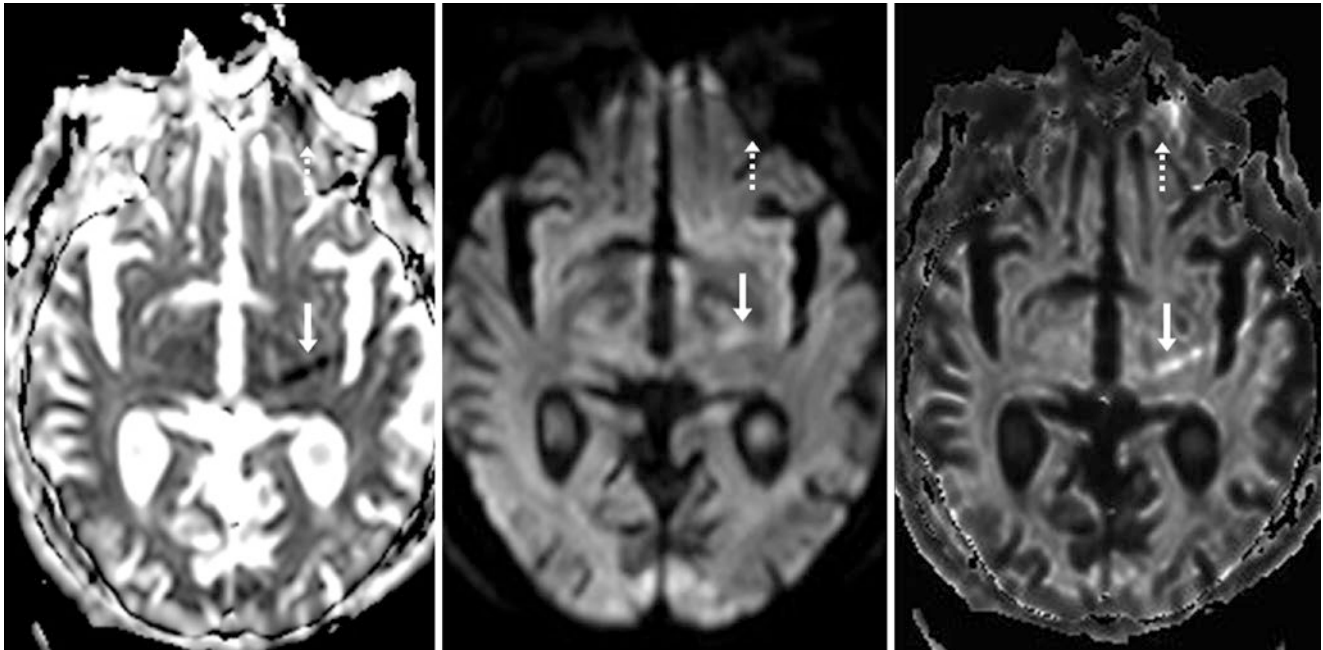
80-year-old with a negative 3 T MRI demonstrating a left thalamic unfolding artifact (*arrows*) on an ADC map (*left*) and DWI (*middle*), worsened on “exponential” DWI (*right*), likely from frontal
